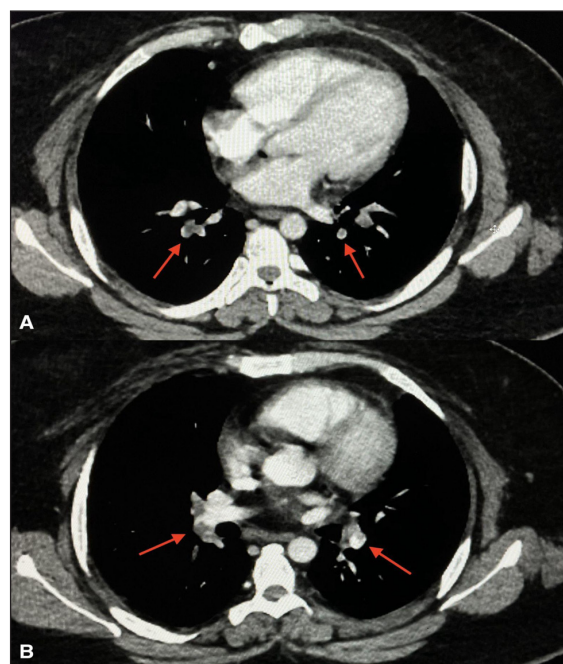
Contrast-enhanced computed tomography chest hypodense filling defects in the upper and lower lobar pulmonary artery branches bilaterally: (A) hypodense filling defects in the bilateral pulmonary artery branches (red arrows) and (B) extension of thrombus in the right and left pulmonary artery branches (red arrows).
